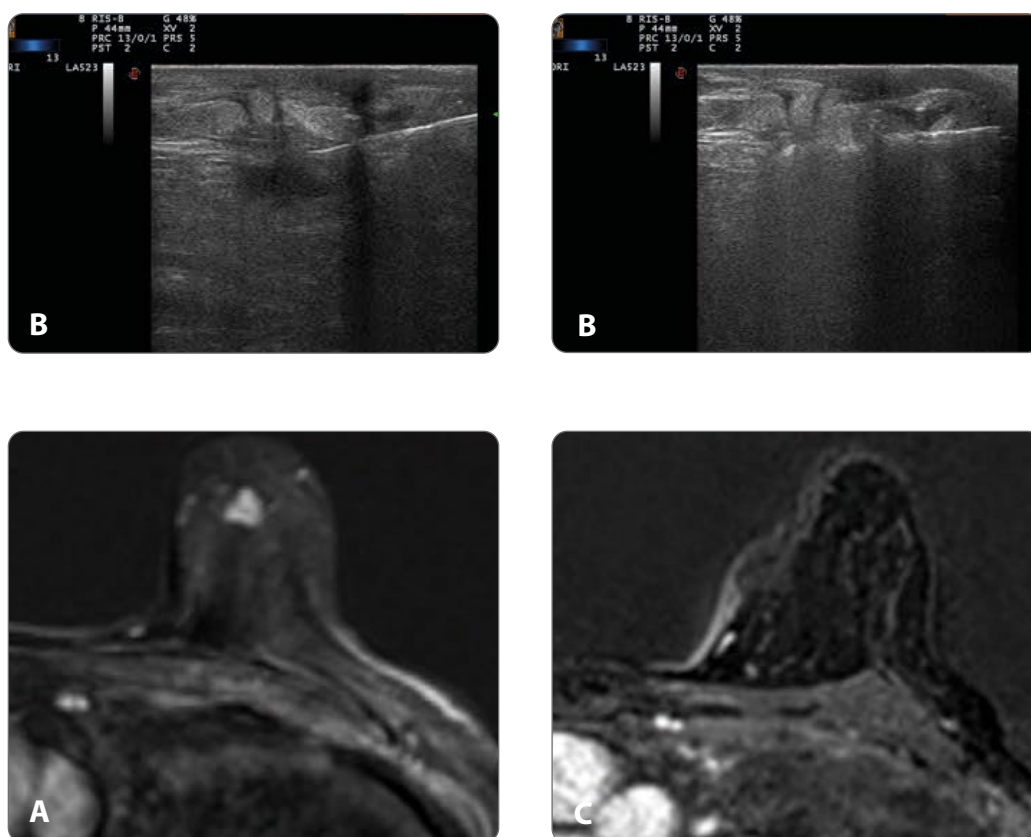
a) MRI image of a infiltrant tumour in the Upper Outer quadrant of right breast that was treated with EchoLaser Thermal Ablation; b) Us image of needle insertion in the breast tumour and end of laser treatment; c) MRI image performed 12 months after the treatment showed no impregnation in treated area corresponding to complete ablation. Images by courtesy of Dr. Jacopo Nori (Careggi Hospital, Florence).
